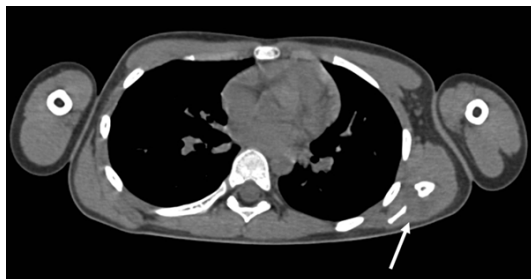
Axial computed tomography scan reveals a round soft-tissue mass penetrating into both the anterior and posterior cortices of the left scapula (the area indicated by the white arrow).
